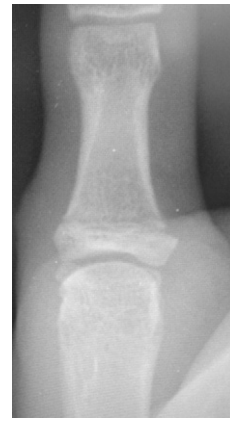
Radiograph of the same patient of Figure 9 showing consolidation of the fracture at 9 weeks after surgery, 1 month after pin removal.
